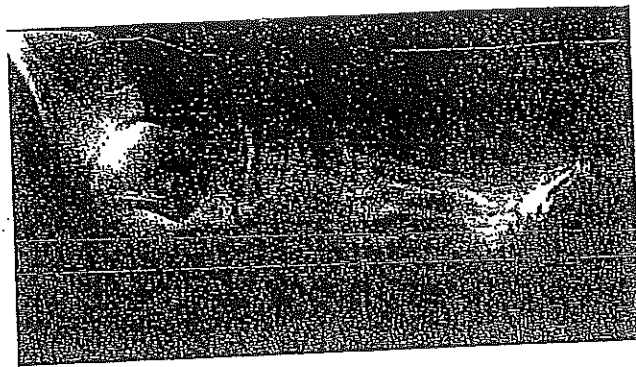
Eight-year postoperative radiograph of bony regrowth at base of proximal phalanx.
